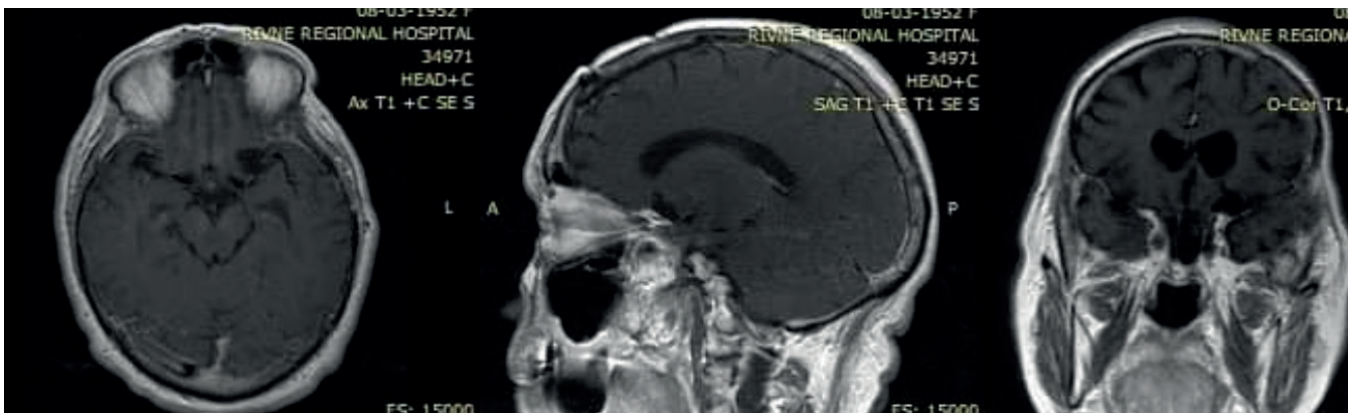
Last follow-up MRI three years after surgery without any sign of recurrence.
